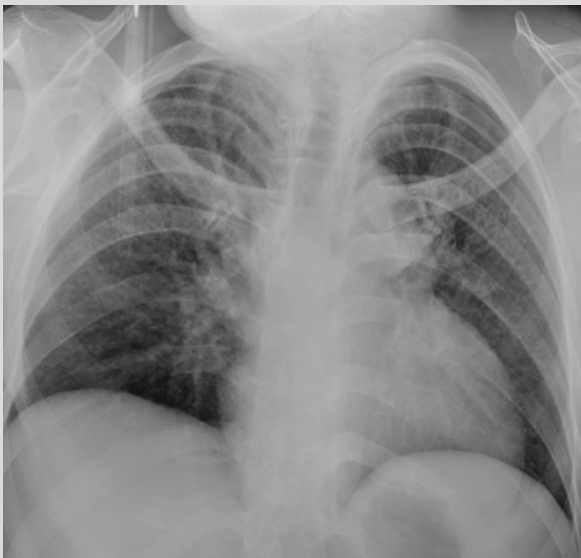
Pulmonary malaria (interstitial pneumonia type). X-ray demonstrates more thickened and blurry lung markings in both lungs as well as reticular and small spots of shadows with increased density
